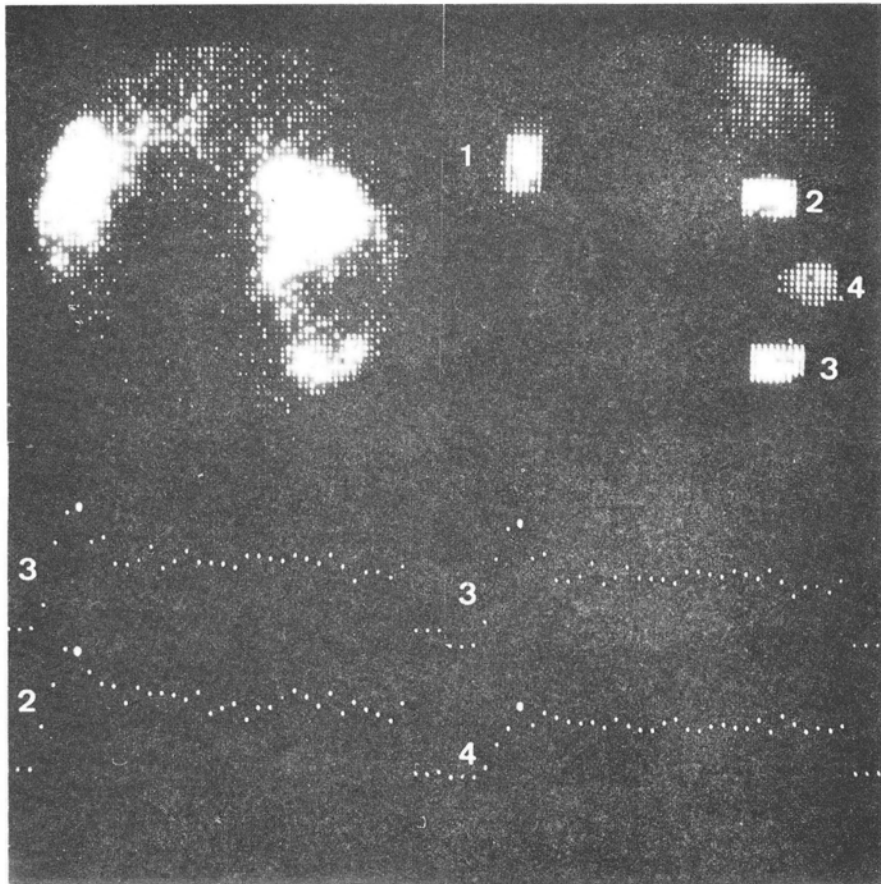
b) Store scintigram, regions of interest and integral curves after Pertechnetate: initial peak followed by decreasing with the exclusion of region 4 corresponding to a central necrosis.
